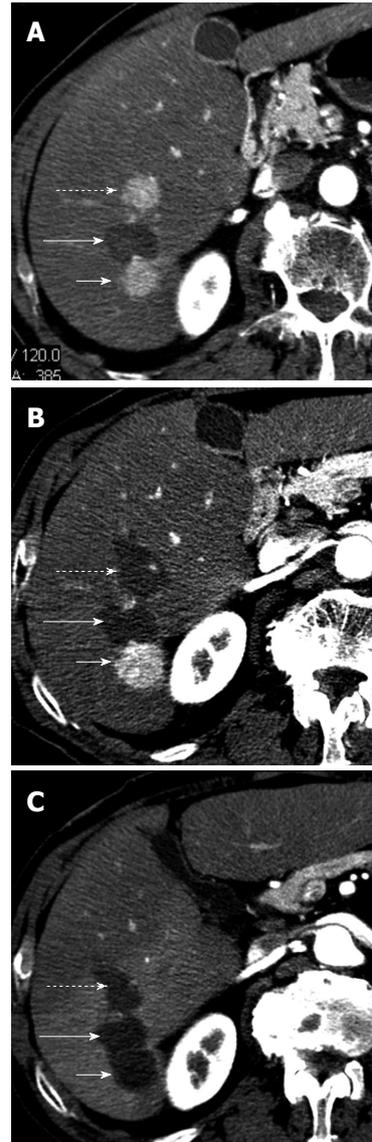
Hepatocellular carcinoma after multiple radiofrequency ablations. A: Arterial phase computed tomography (CT) obtained 8 mo after radiofrequency ablation shows two new enhancing hepatocellular carcinoma (HCC) nodules located anteriorly (dotted arrow) and posteriorly (short arrow) to ablated HCC (long arrow). These findings suggest occurrence of new HCC nodules; B: Arterial phase CT obtained 2 mo after additional radiofrequency (RF) ablation shows that HCC nodule located anteriorly (dotted arrow) has been replaced by a hypoattenuating, non enhancing area (arrow) that is larger than preexisting tumor. These findings suggest complete necrosis. Posteriorly located HCC (short arrow) increased in size; C: Arterial phase CT obtained 2 mo after posterior. HCC had been replaced by a hypoattenuating, nonenhancing ablation area as a result of additional RF ablation. This example shows that RF ablation is a repeatable procedure.
